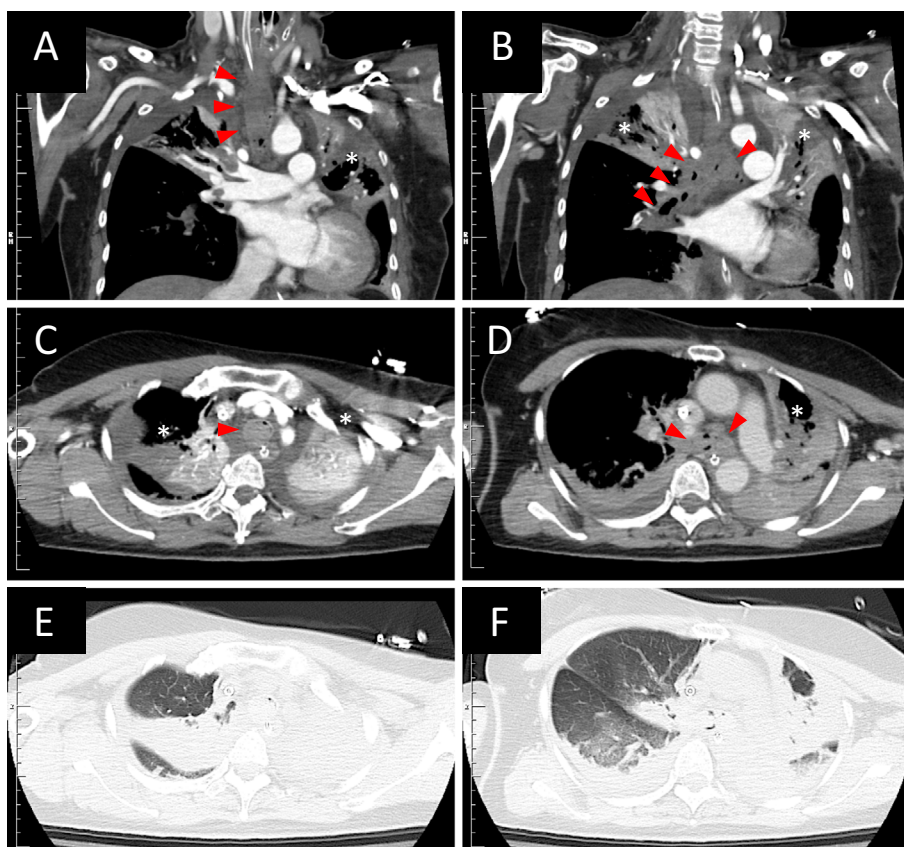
Contrast-enhanced CT images. Coronal (A, B) and axial (C, D, E, F) images of the chest before removal of a blood clot on the fourth hospitalization day. CT imaging revealed a blood clot obstructing the space from the trachea to the bilateral mainstem bronchi (red arrows). Atelectasis was seen in the bilateral upper lobe, but active bleeding was not found (asterisks). CT: computed tomography
